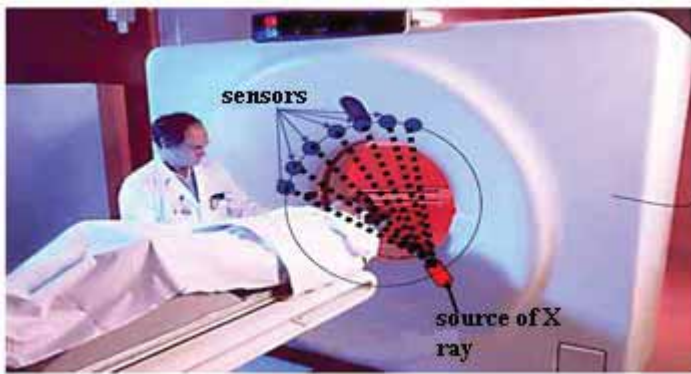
Emission scanner of X-rays
